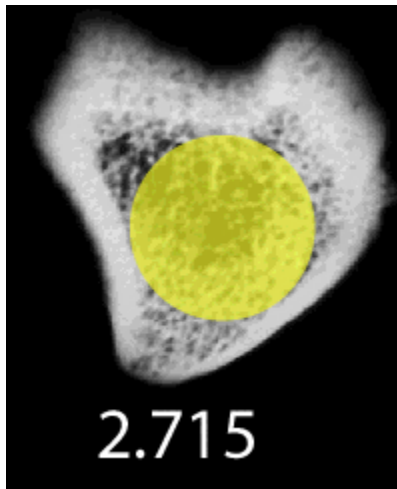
Sample radiograph with the maximum endocortical circle.
